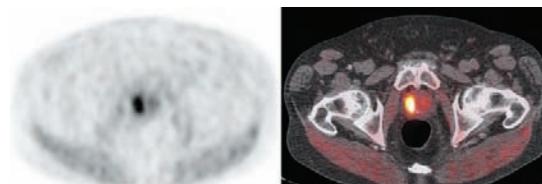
Patient with history of prostate cancer treated with curative-intent radiotherapy who presented with increased serum PSA. ¹⁸F-FCH PET/CT demonstrated intense uptake at the right prostate bed which was proven to be local recurrence. Patient was referred for salvage therapy.
